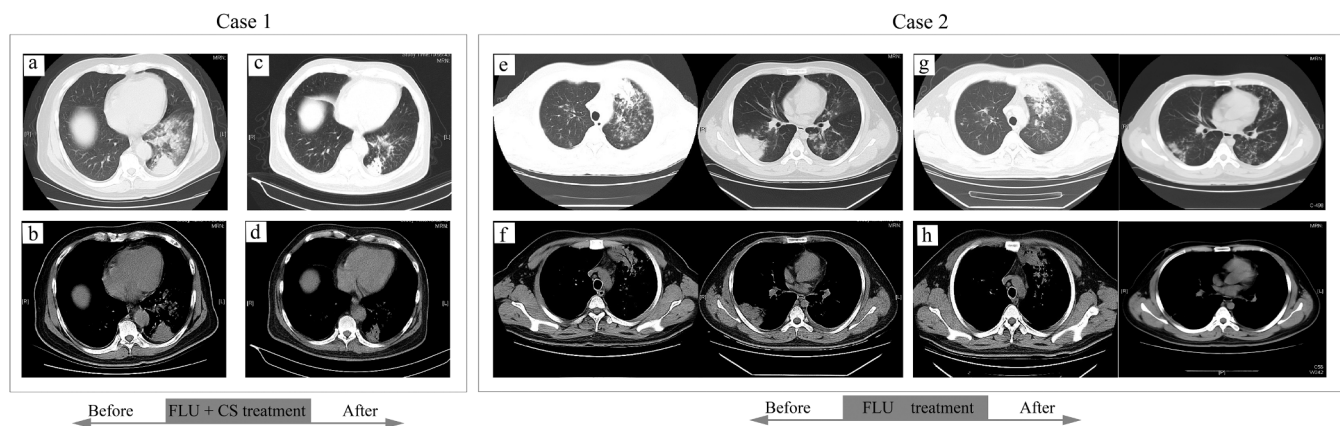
Chest computed tomography (CT) scan images before and after treatment. Case 1, (a-b) Chest CT scan images showed multiple high-density shadows in the lower lobe of the left lung with indistinct margins, partial lung tissue consolidation, small amount of pleural effusion. (c-d) The consolidation had been resolved obviously after the treatment. Case 2, (e-f) Chest CT scan images show consolidation of the left upper lung and the right lower lung, in which the left upper lung shadow is distributed along the bronchial vascular bundle with uneven density. (g-h) After treatment, the consolidation of the lower right lung was obviously absorbed, and the consolidation of the upper left lung was slightly improved after the treatment. Abbreviations: FLU, fluconazole, CS, Corticosteroids.
